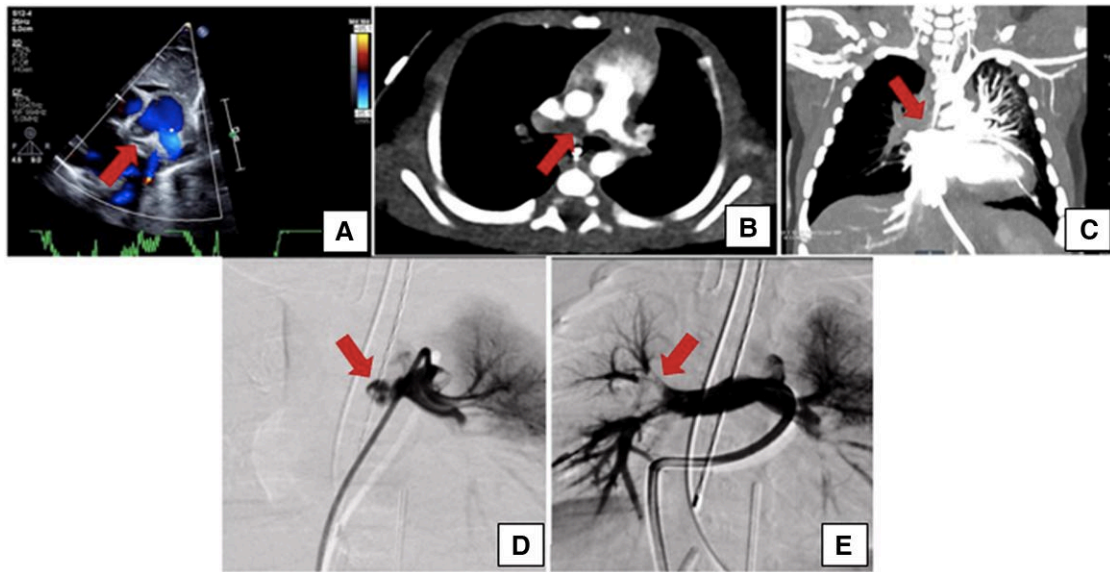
Diagnostic imaging. (A) Initial filling defect through the right pulmonary artery seen on echocardiography (indicated by arrow). (B and C) First computed tomography scan demonstrating filling defect through the right pulmonary artery on axial (left) and coronal planes (right) as indicated by arrows. (D and E) Contrast filling defect through the right pulmonary artery (indicated by arrows) seen by digital subtraction angiography in catheterization lab before (D) and improved after (E) mechanical thrombectomy and balloon angioplasty.
